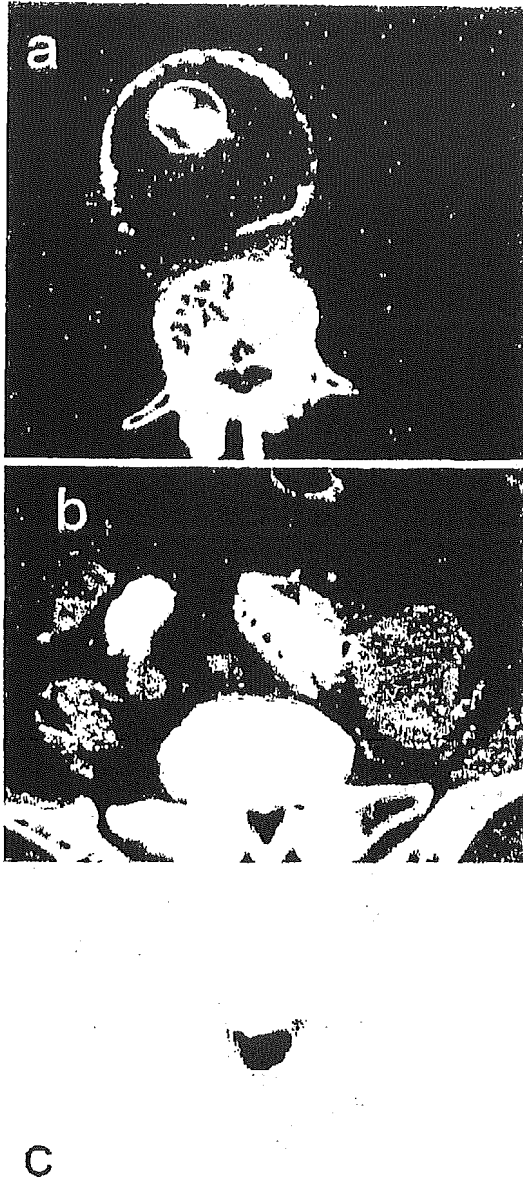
Preoperative CT showed a tear of the posterior wall (a) and an abscess in the left psoas muscle (b). FDG-PET showed marked accumulation behind the AAA (c).
